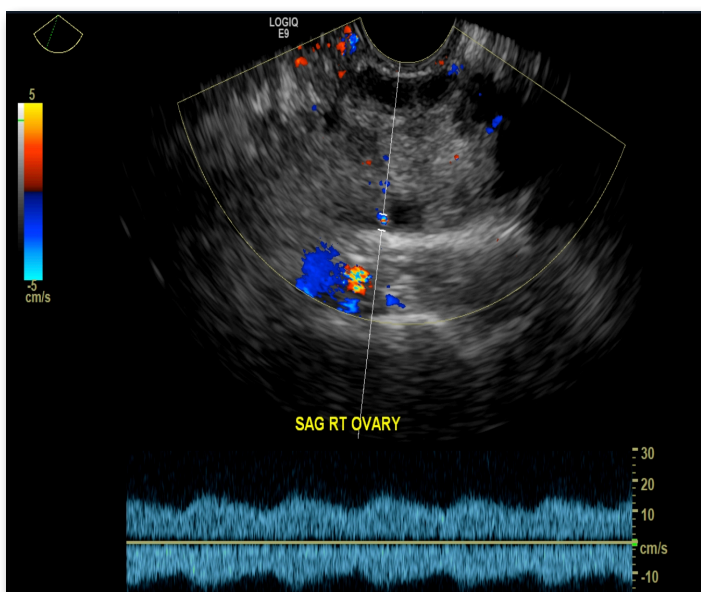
Transvaginal ultrasound still image showing an enlarged right ovary with a preserved doppler arterial flow.
